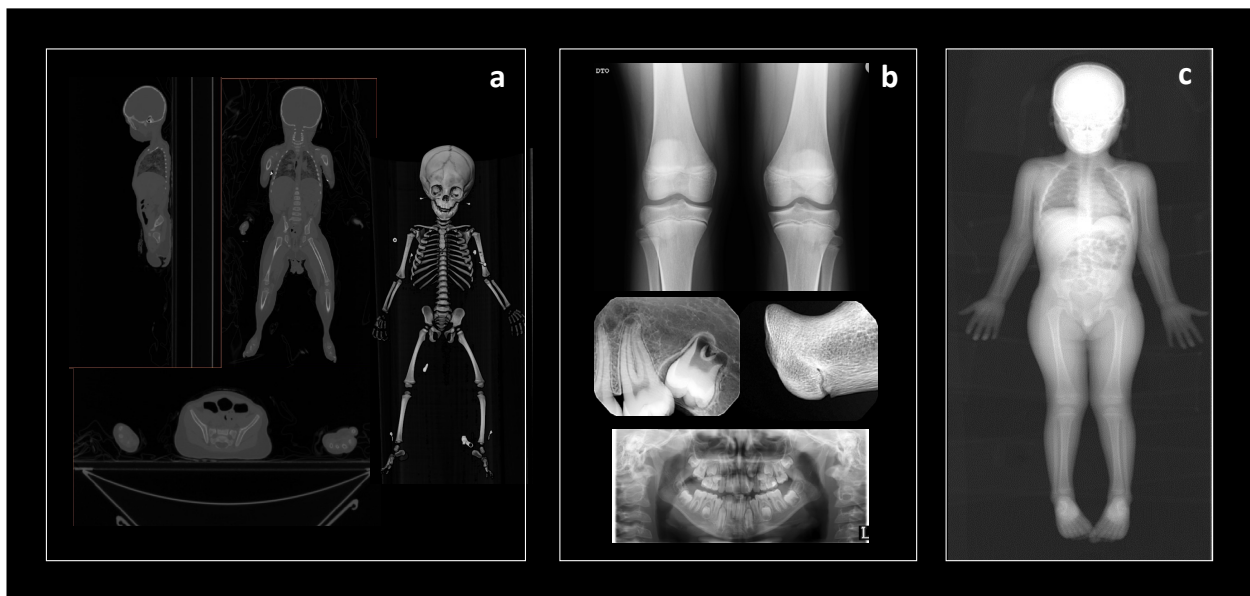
Types of medical images used for data collection in the SVAD. (a) full-body CT scan (sagittal, frontal, transverse views) and volume rendering of the skeleton; (b) conventional radiographs, examples herein of the knees (top), teeth and proximal radius (middle), and teeth (bottom); and (c) full-body Lodox Statscan.
